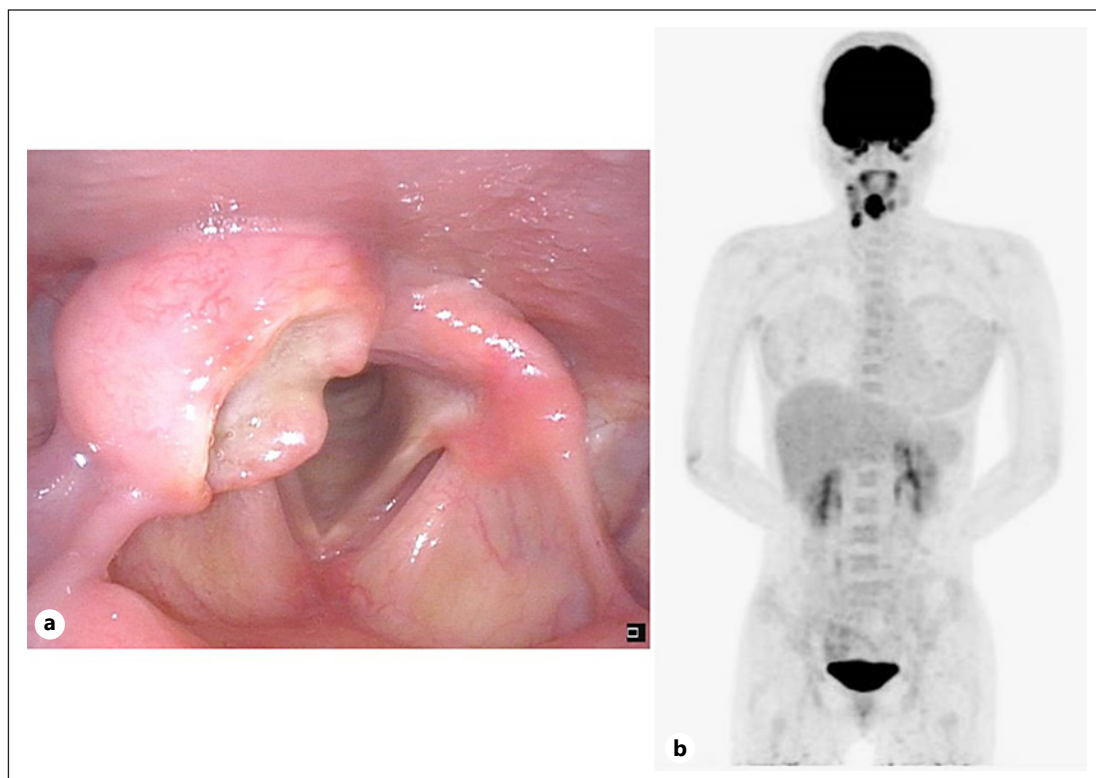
Findings on initial examination. Ulcerated swelling in the right laryngeal arytenoid shown by laryngeal endoscopy (shown in a). SUVmax of the larynx (early 11.15, late 12.63), multiple SUVmax values of the right cervical lymph nodes (Lv II: early 6.02, late 6.79 Lv III: early 9.72, late 10.84), and FDG accumulation in pretreatment FDG-PET (shown in b).
